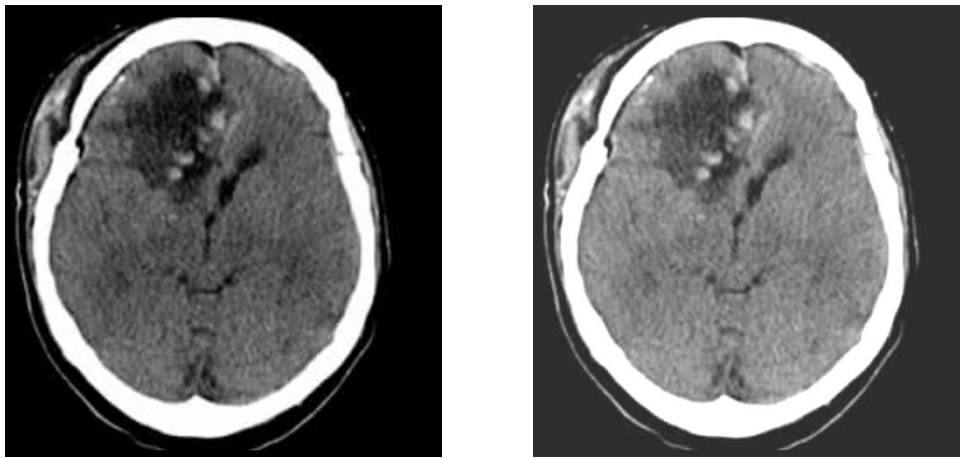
Postoperative CT showing huge olfactory groove meningioma after excision.
